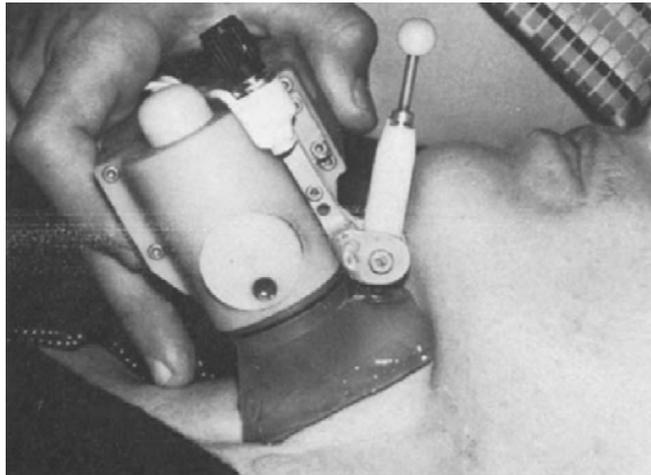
'Duplex III' transducer developed by Philips et al (1980). The offset Doppler probe is seen on the right of the transducer. Reproduced from *Ultrasound Med Biol*, Vol. no. 6; Phillips DJ, Powers JE, Eyer MK, Blackshear Jr WM, Bodily KC, Strandness Jr DE, Baker DW; Detection of peripheral vascular disease using the Duplex scanner III, pp. 205-218, copyright Elsevier (1980).
